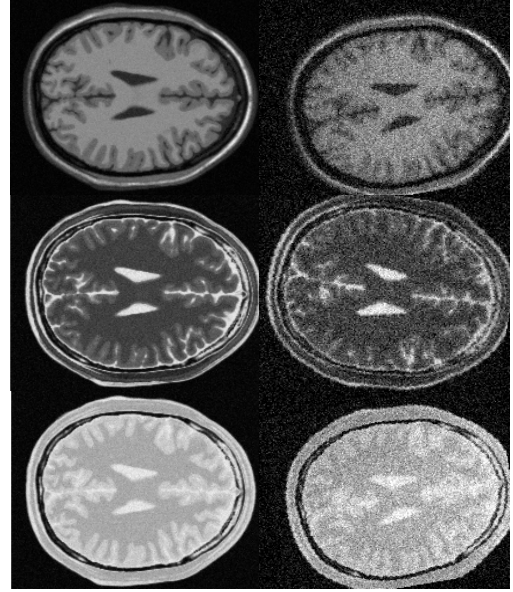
Sample test images: Left are the T1, T2 and PD target MRI and on the right, the corresponding source MRI including INU and Gaussian noise (see Table 1).
